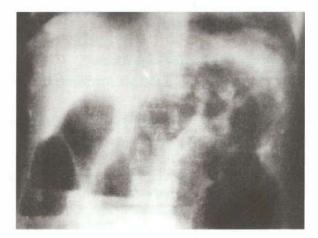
Plain X-ray abdomen showing multiple gas and fluid levels
